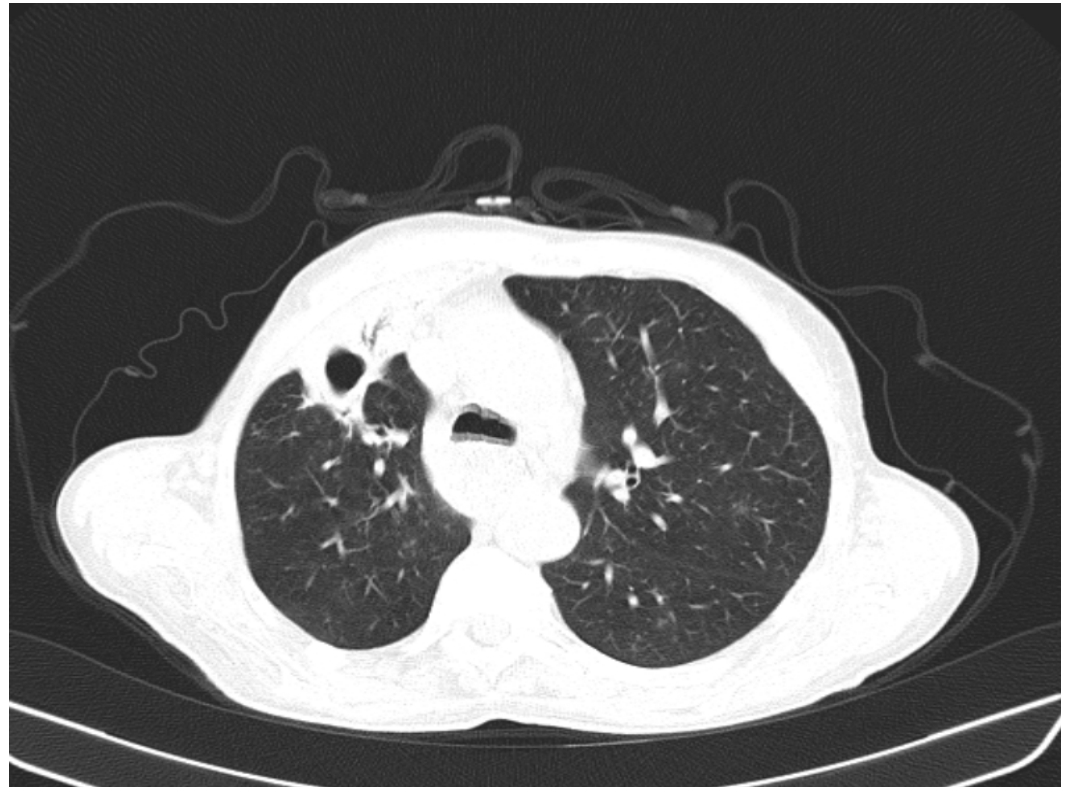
Follow-up after 3 months: computed tomography scan of the chest abscessed lesion already in the resolution phase right upper lobe.
